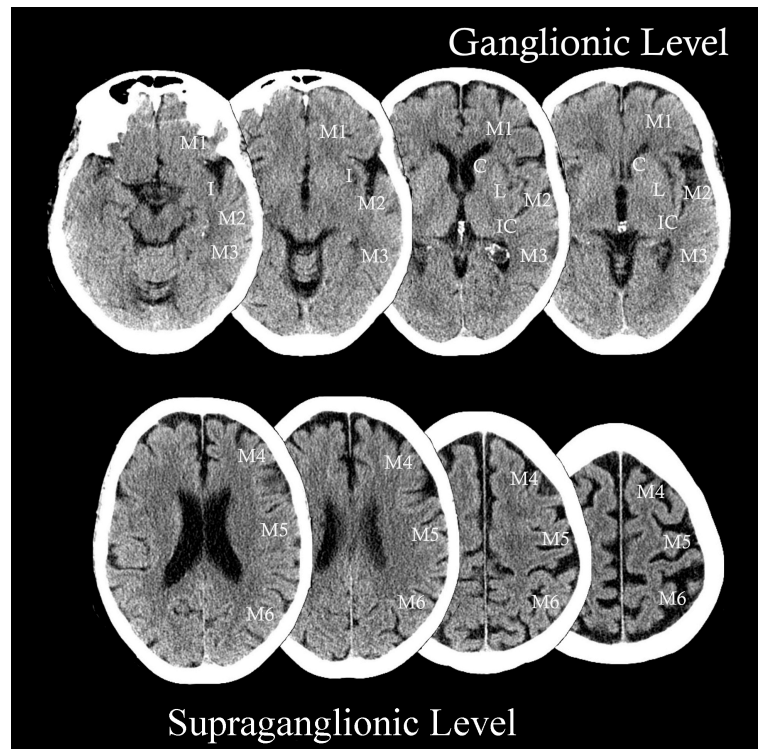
Labeled ASPECTS regions on a non-contrast CT Scan.
